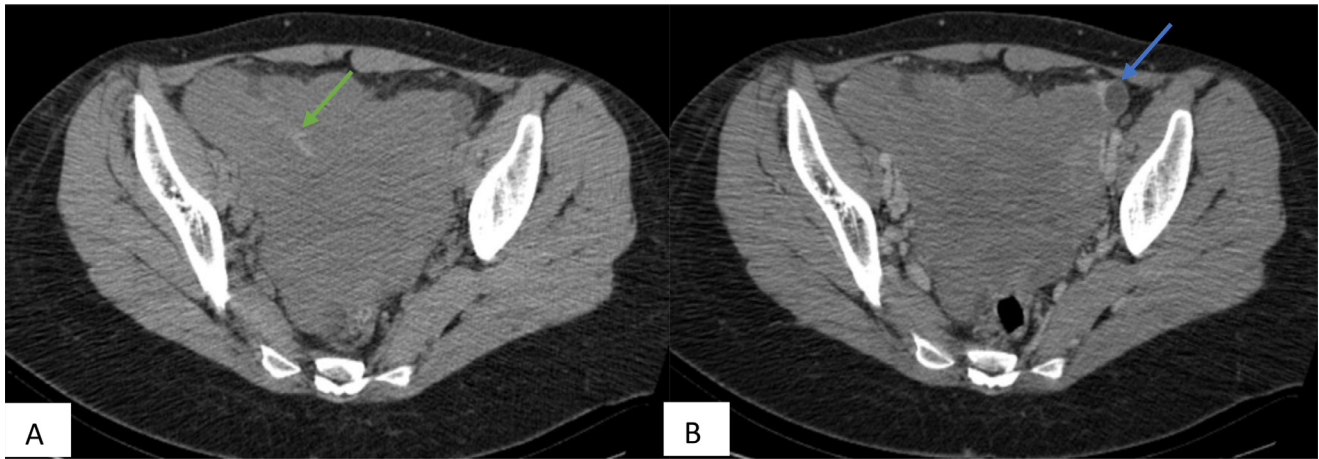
An axial computed tomography scan of the abdomen and pelvis before (A) and after contrast (B) showed bilateral ovarian tumors with heterogeneous contrast enhancement, including hemorrhagic (green arrow) and cystic areas (blue arrow).
